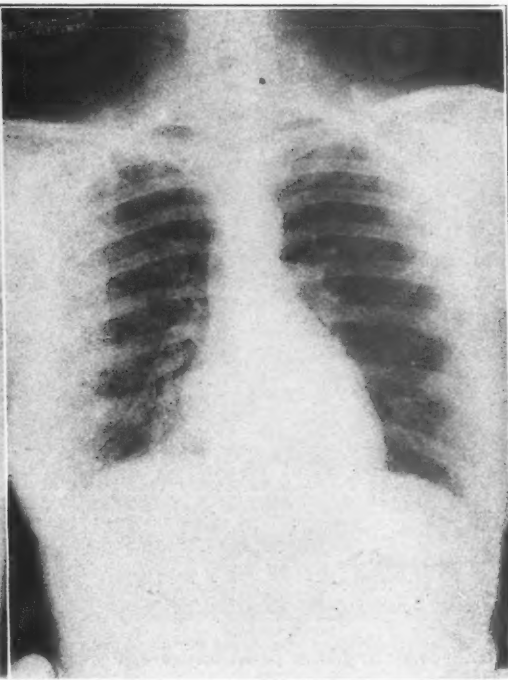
X-ray of lung, same patient, February 1, showing complete disappearance of abscess shadows.
